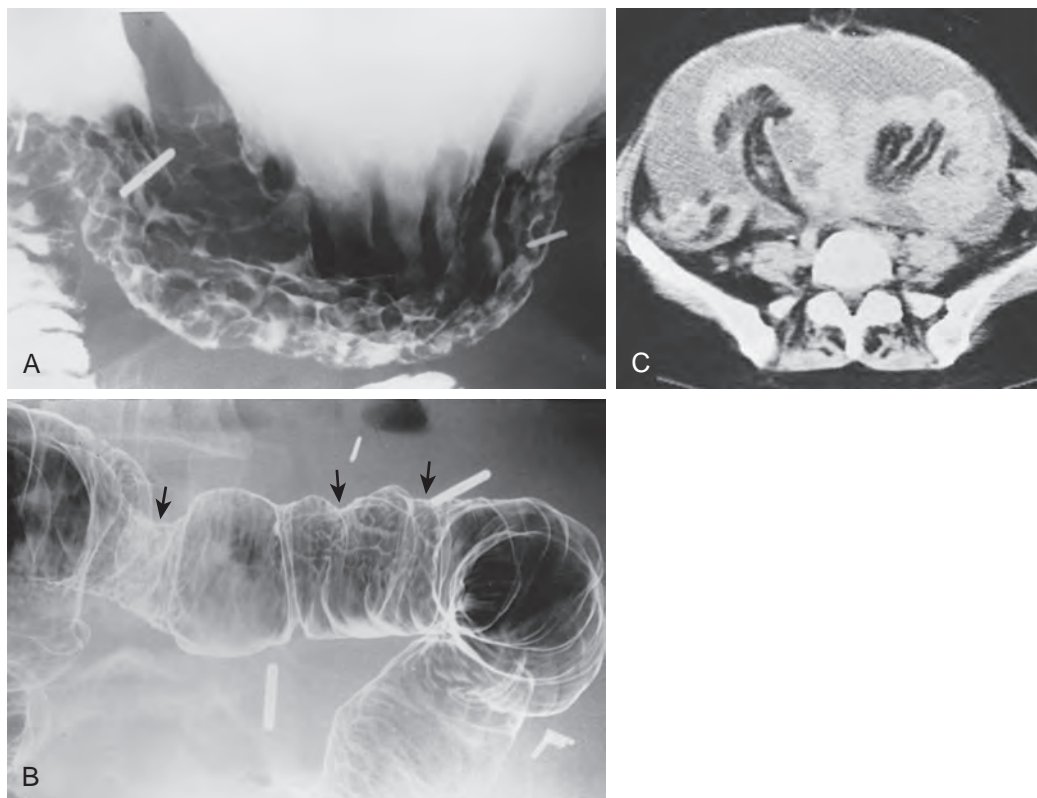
Gastric and colonic involvement by omental metastases from ovarian carcinoma. A. Upper GI study shows spiculated folds and nodularity on the greater curvature of the gastric antrum and body as a result of direct extension of tumor from the greater omentum. B. Barium enema shows spiculation and tethering of the superior border of the transverse colon (arrows) as a result of simultaneous colonic involvement by omental tumor. C. In another patient, CT scan reveals ascites with a bulky omental cake separating the small bowel from the anterior abdominal wall. (C from Laufer I, Levine MS [eds]: *Double Contrast Gastrointestinal Radiology*, 2nd ed. Philadelphia, WB Saunders, 1992.)
